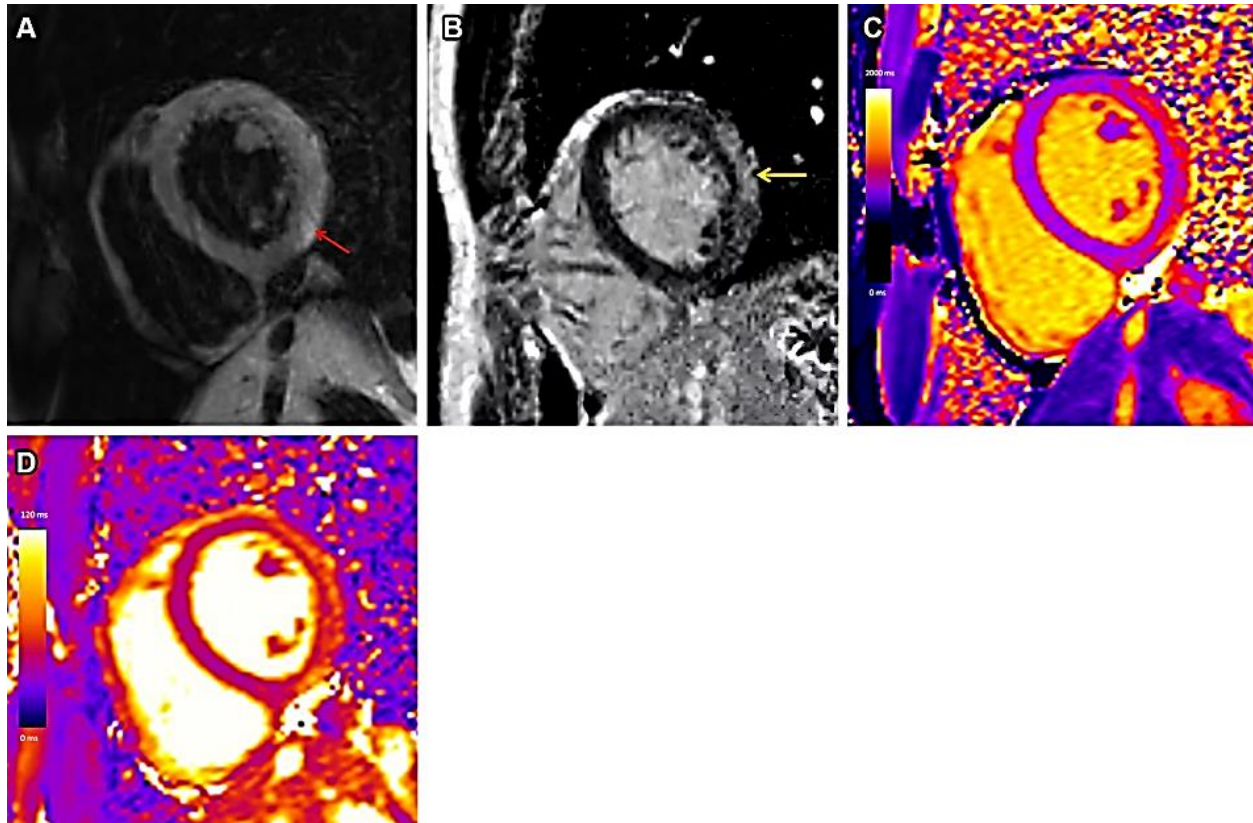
Myocarditis in a 20-year-old man with acute COVID-19 who was admitted to the hospital with chest pain and an increased cardiac troponin level. (A) Cardiac T2-weighted short-axis MR image shows focal hyperintensity in the lateral wall suggestive of edema (arrow). (B) Short-axis MR image shows corresponding linear subepicardial LGE (arrow). (C, D) Short-axis native T1 (C) and T2 (D) maps show increased T1 and T2 times at the subepicardial anterolateral and inferolateral walls, respectively (Quoted from 10).
